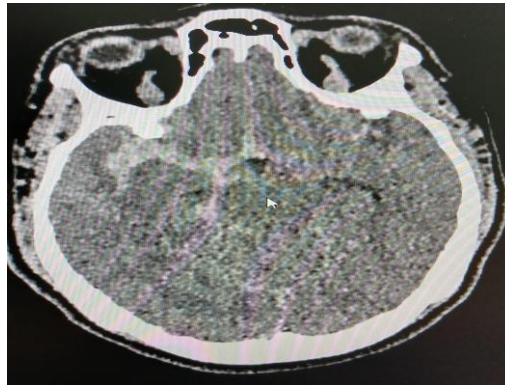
CT scan revealing the subarachnoid haemorrhage.
